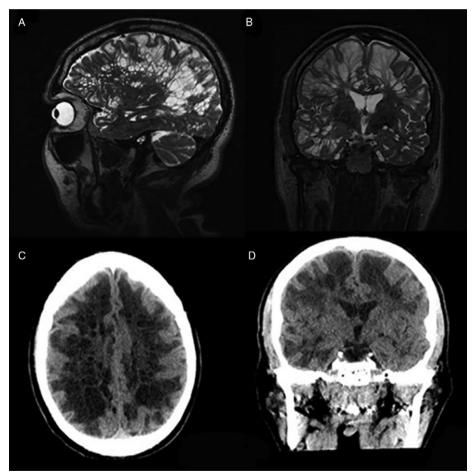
(A) Sagittal and (B) Coronal T2-weighted MRI images showing diffuse white matter volume loss and cavitary lesions consistent with dysmyelination or diffuse cystic leukodystrophy. (C) Axial and (D) Coronal CT head images during initial presentation that revealed chronic-appearing diffuse white matter hypodensities and cystic changes. CT findings prompted further workup.
